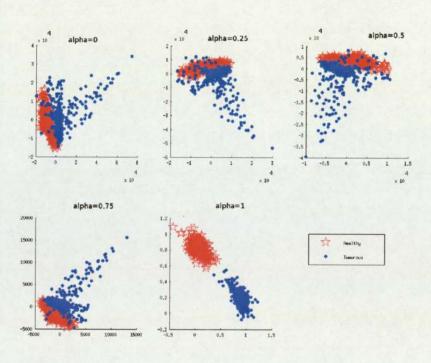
NeuroScale of healthy versus tumorous using Minkowski distance of order 4 and the combination of MRI and MRSI data.
